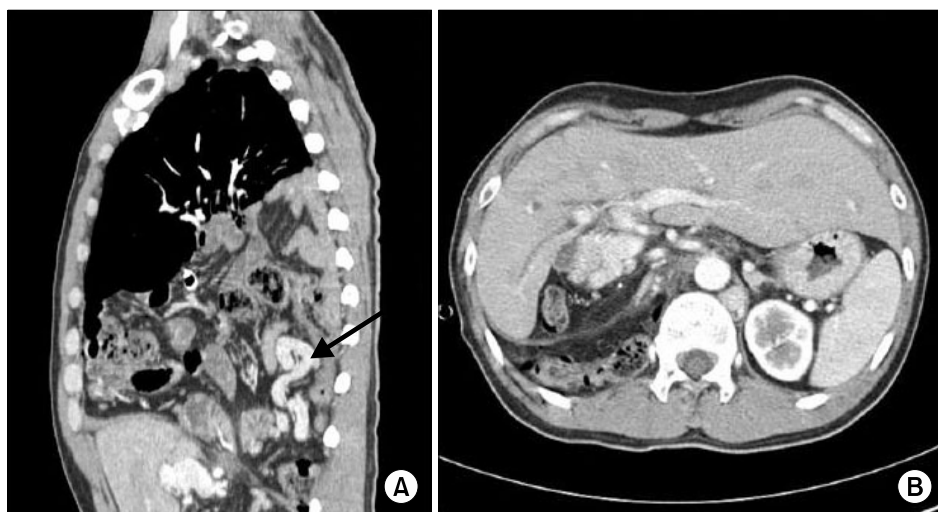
(A) The upper computed tomography scan shows herniation of various abdominal organs with engorged mesenteric vein (arrow). (B) And the lower panel shows hypoplasia of right hepatic lobe with compensatory hyperplasia of left hepatic lobe.
